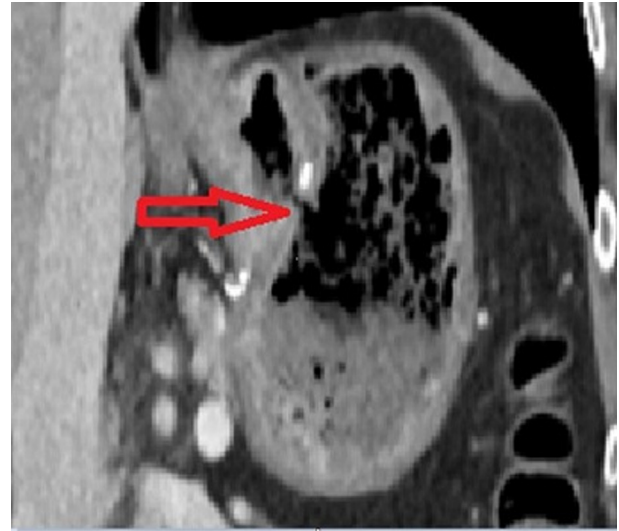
CT scan of the abdomen/pelvis showing the gastrogastric fistula.
